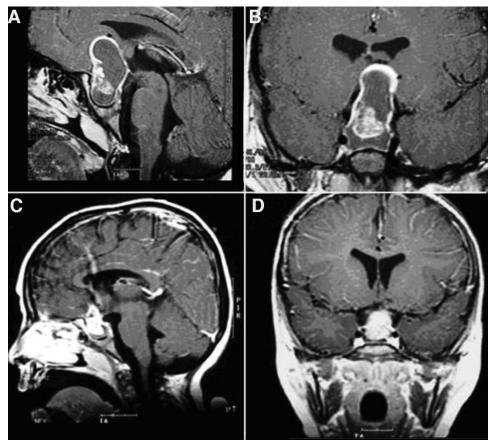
Magnetic resonance images showing high-volume CPs and posttreatment CPs that have significantly decreased in size after 3 cycles of IFN α 2A and 5 years of follow-up: pretreatment images (A and B), posttreatment image (C), and 5-year follow-up image (D).
